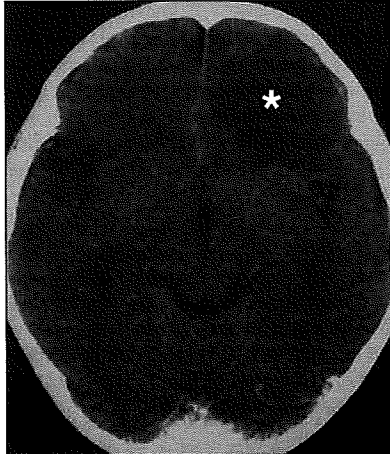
9-year-old boy with brain abscess on 31st day after bone marrow transplantation. Patient underwent hematopoietic stem cell transplantation (HSCT) for acute myelocytic leukemia. Acute graft-versus-host disease occurred on 16th day after HSCT, and cyclosporine was administered. Serum WBC count was 11,800/ μ L with 2% lymphocytes (normal, 30–50%). Contrast-enhanced CT scan shows uniform low-attenuation area (*asterisk*) with subtle mass effect. No surrounding contrast enhancement is present. Deformation in left sylvian fissure is subtle for size of mass.
